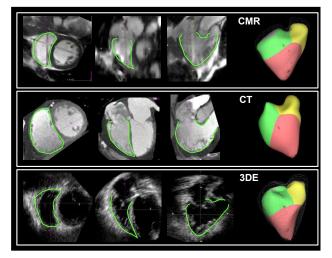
Volumetric analysis of CMR (top), CCT (middle) and RT3DE (bottom) images obtained in one patient. Shown from left to right: RV boundaries initialized in a mid-ventricular short-axis view, apical four-chamber view and coronal view, shown along with the resultant calculated RV endocardial 3D surfaces (right), with the solid cast representing end-systole and the wire frame representing end-diastole.
